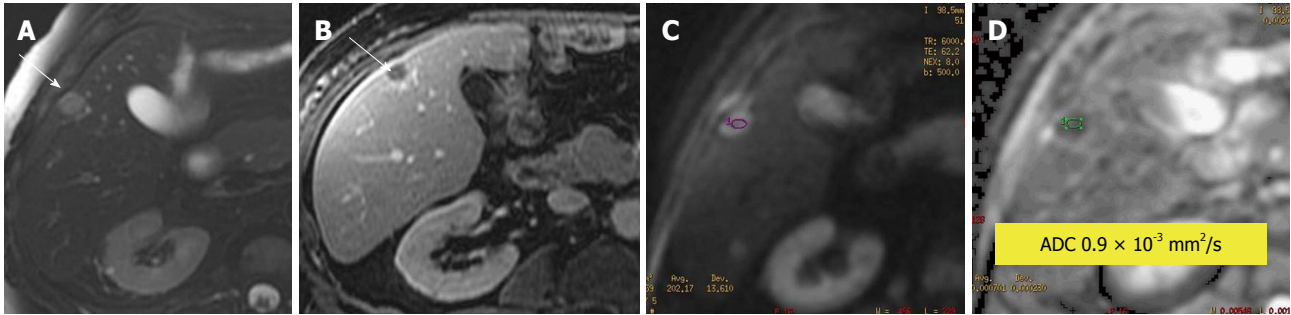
Leiomyosarcoma metastasis to liver. A: Axial fat-suppressed, T2-weighted (T2W) Fast Spin-Echo image; B: Post contrast T1-weighted gradient recalled-echo image; C: Diffusion-weighted imaging; D: Apparent diffusion coefficient (ADC) map. The T2W hyperintense and rim-enhancing lesion is a pathologically established metastasis (arrow) with an ADC value of $0.9 \times 10^{-3} \text{ mm}^2/\text{s}$, indicating impeded diffusion likely due to its highly cellular nature.
